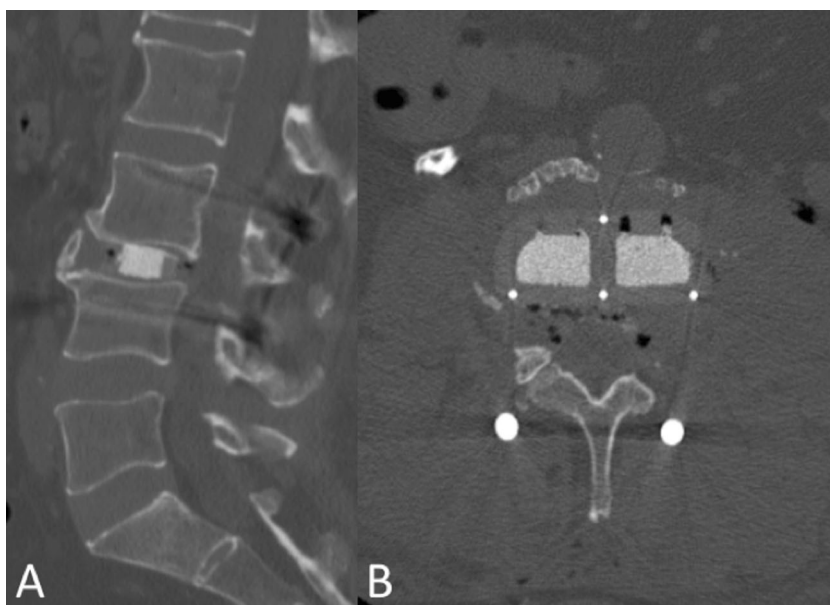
Postoperative lumbar CT scanner, (a) sagittal and (b) axial, showing the XLIF cage in place, a complete reduction of the retrolisthesis and an open L3 foramen on the right side (indirect decompression)
